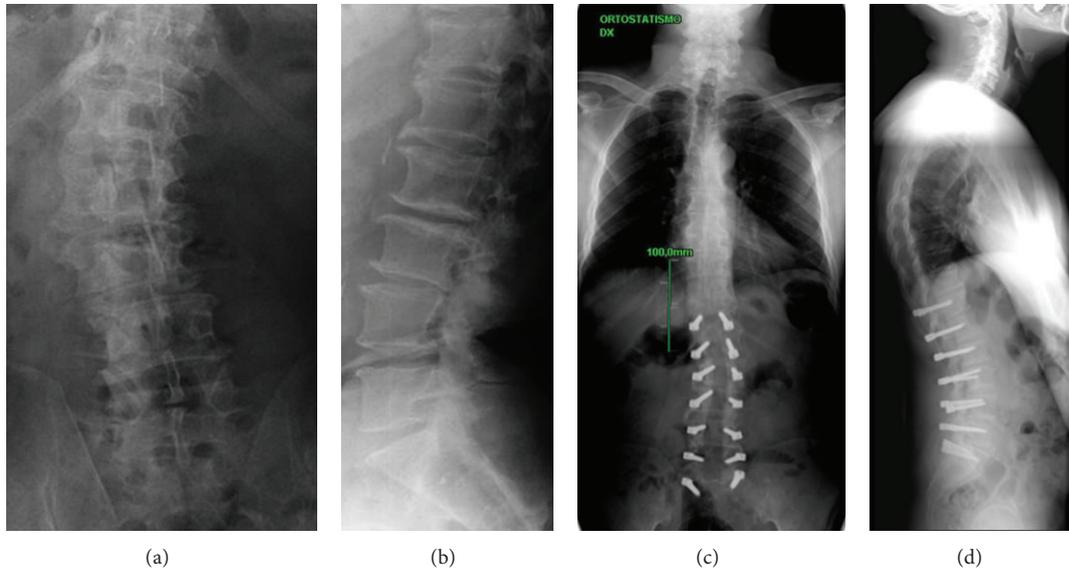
A 73-year-old woman. Degenerative lumbar scoliosis with good sagittal balance ((a)-(b)), associated with stenosis of the vertebral canal. Treatment: T12-S1 dynamic stabilization and decompressive laminectomy. Five-year postoperative radiographs showing stable scoliosis correction with maintained sagittal balance ((c)-(d)).
